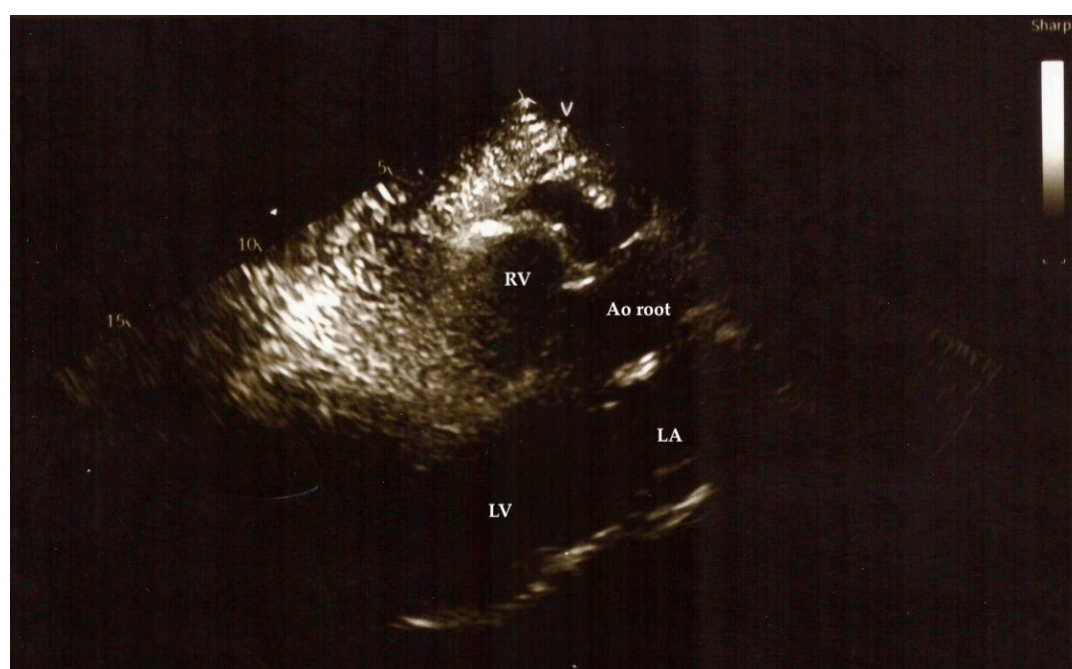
TTE of Clinical Case 1: The parasternal long-axis view is suboptimal due to marked cardiac levoposition with interposition of aerated lung tissue, precluding adequate visualization and reliable assessment of cardiac structures and function from this window; Ao – aortic; LA – left atrium; LV – left ventricle; RV – right ventricle.
